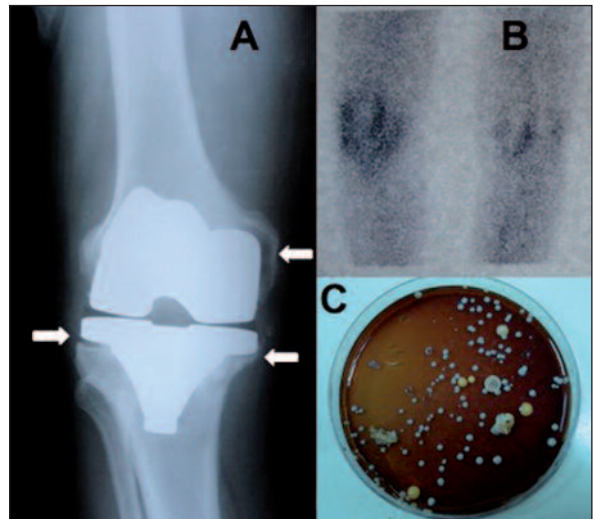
A- The x-ray at the presentation of the patient. The arrows demonstrate the osteolysis due to infection, B- The Tc-99m scan in favour of septic loosening, C- Proliferation of fungal colonies
